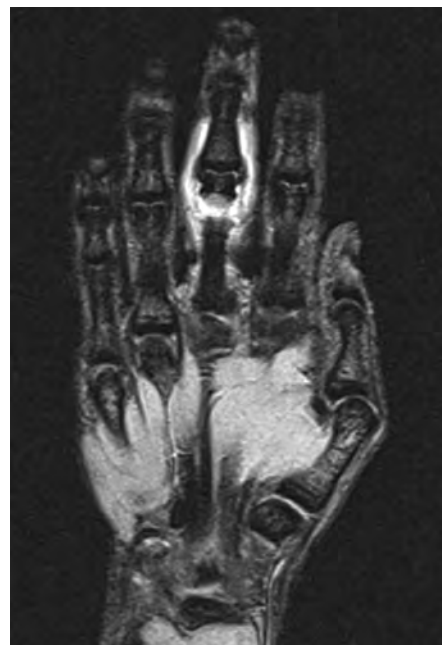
Synovial hypertrophy and effusion were present in the hand MRI
